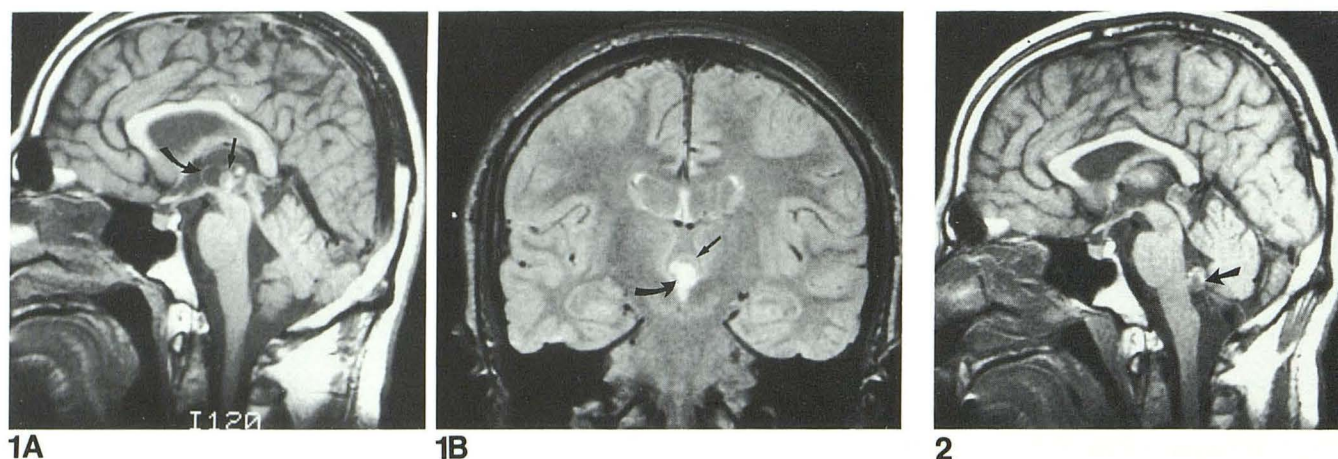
A, Sagittal T1-weighted (500/20) (TR/TE) MR image demonstrates a neurocysticercosis cyst with a high-intensity mural nodule in the third ventricle. The cyst wall (*curved arrow*) and scolex (*straight arrow*) are identified.
